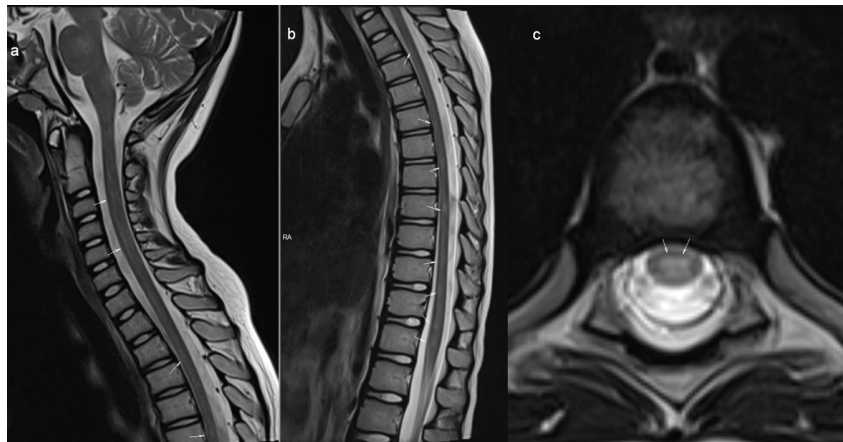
(a-c): Sagittal plane T2-weighted images of the spinal cord (a, b) reveal multiple patchy expansile T2-hyperintense lesions that tend to merge with each other, compatible with longitudinally extensive spinal cord involvement (arrows). Note the extension into the brainstem. An axial plane T2-weighted image of the spinal cord (c) demonstrates the central involvement of the cord (arrows)
